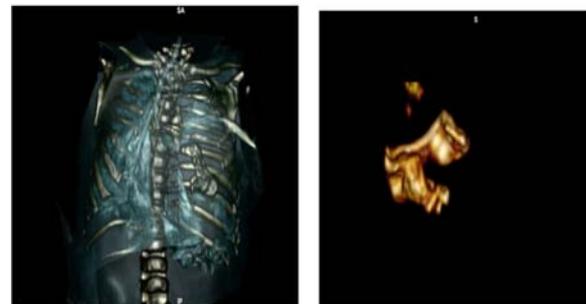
CT scan in video form showing mass centered by opacity of bone density.
